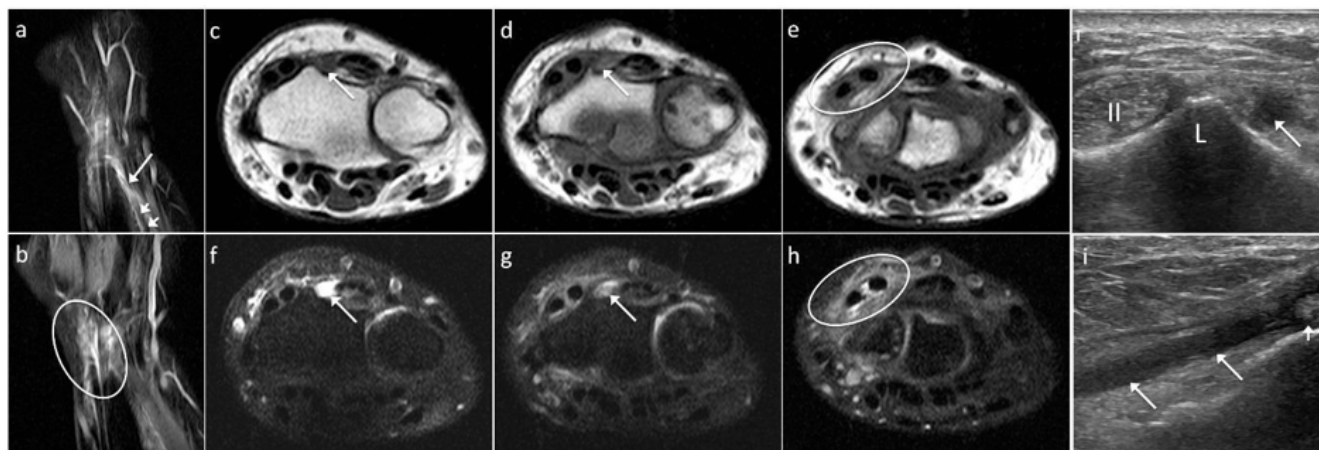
Ultrasound and magnetic resonance images. Coronal proton-density (PD) fat-saturated (a), axial T1-weighted (c, d), and axial PD fat-saturated (f, g) magnetic resonance (MR) images show fluid signal intensity instead of the normal tendon structure due to rupture in the third extensor tendon compartment (long arrows). Synovial effusion and surrounding soft tissue edema are also seen in the tendon sheath of the second extensor compartment on the same images (circles). Ultrasound examination in axial plane (i), at Lister's tubercle (L), shows the absence of EPL tendon (long arrow) adjacent to the second extensor compartment (II). Longitudinal ultrasound image (j) demonstrates hypochoic echogenity (long arrows) representing torn tendon fibers and fluid in the tenosynovial sheath. The retracted proximal end of EPL tendon is seen on both coronal PD fat-saturated MR (b) and longitudinal ultrasound images (j) (short arrows).
